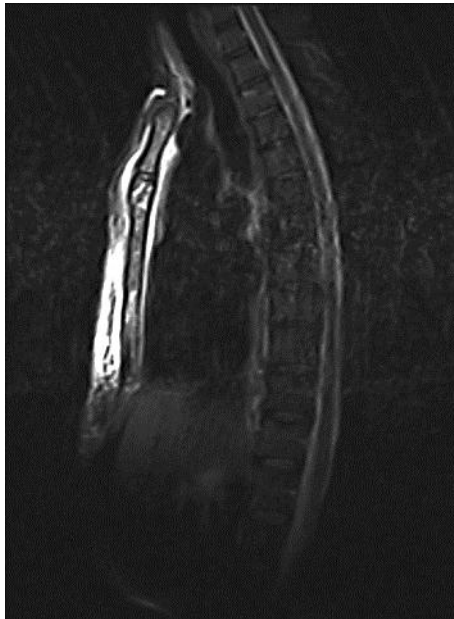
Sternal fracture. A sagittal T2 MRI of the patient's sternum acquired three days after the car accident.
